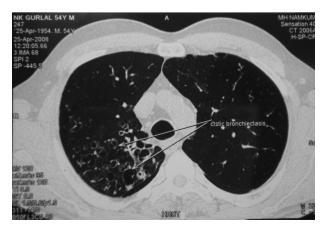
High resolution computed tomogram showing cystic lucencies in right upper lobe.
